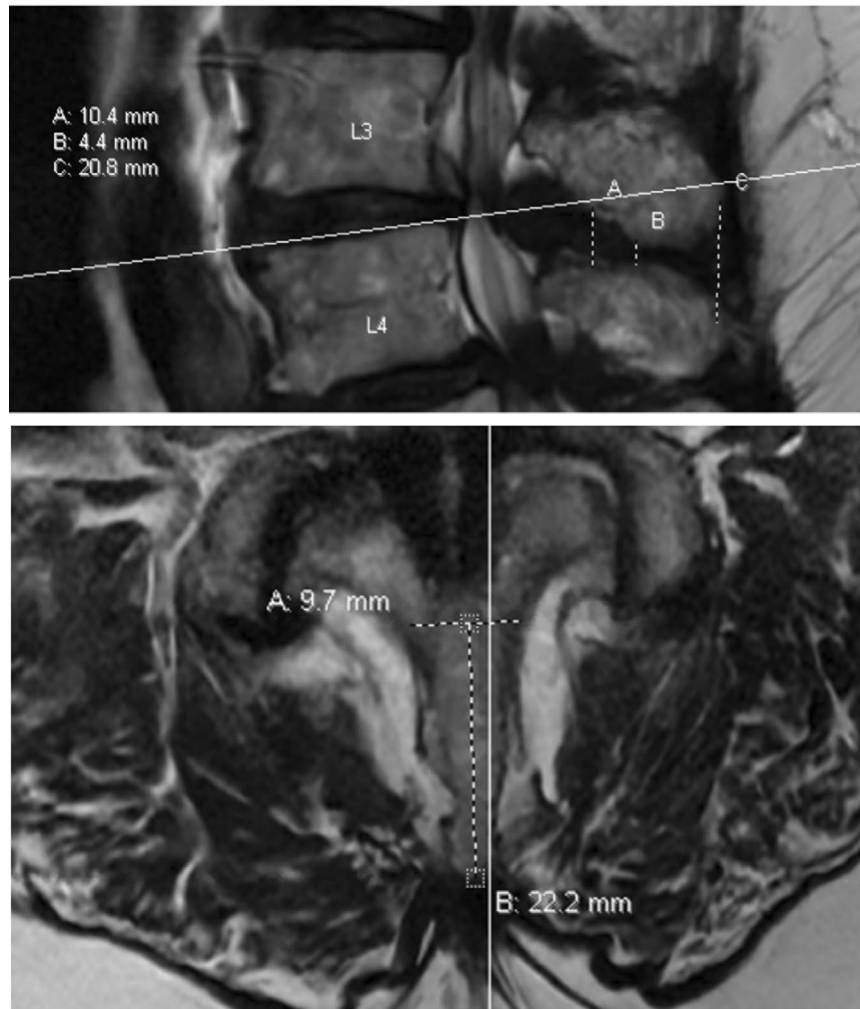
MRI measurements using PACS Workstation at the level of Vertiflex ISS Implementation on preoperative imaging. The scout line is shown in both images for alignment. (A-above) Measurement at the junction of lamina and interspinous process. (B-above) Measurement of smallest space between contiguous spinous processes. (C) Measurement of space between tips of spinous processes. (A-below) Measurement of the width of the spinous process. (B-below) Measurement of the length of the spinous process from the ISS insertion point to the tip of the spinous process.
